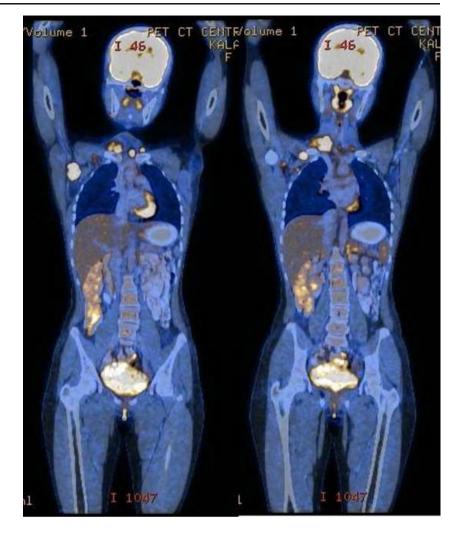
PET-CT scan showing metabolically active uptakes in the recurrent tumor in the supraclavicular fossa and in the multiple bilateral cervical and right axillary lymph nodes
